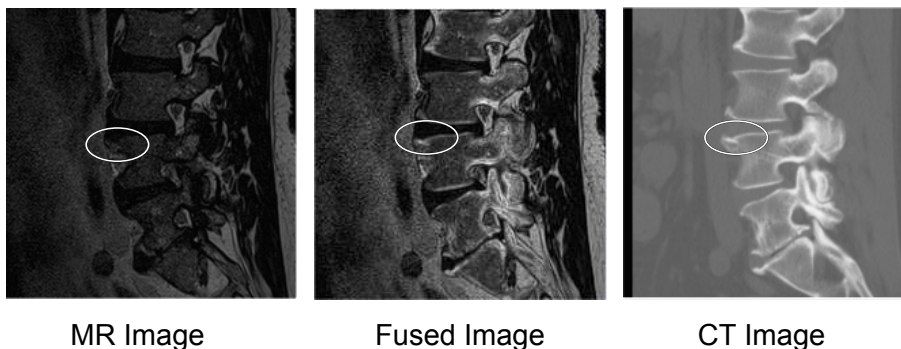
Images of boney spur formation, left MR - osteophyte not identifiable, middle Fused image - the osteophyte is clearly visible along with surrounding soft tissue, right CT image showing the osteophyte, but no soft tissue.
